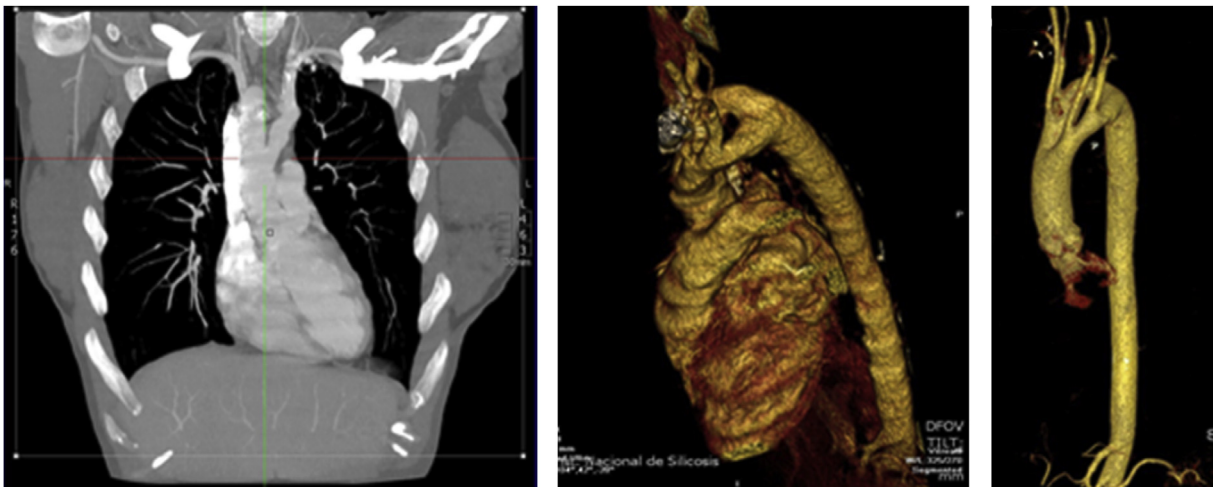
The thoracic CT showed the presence of a double aortic arch that completely surrounded the trachea and the esophagus, conditioning a stenosis of less than 50%.
